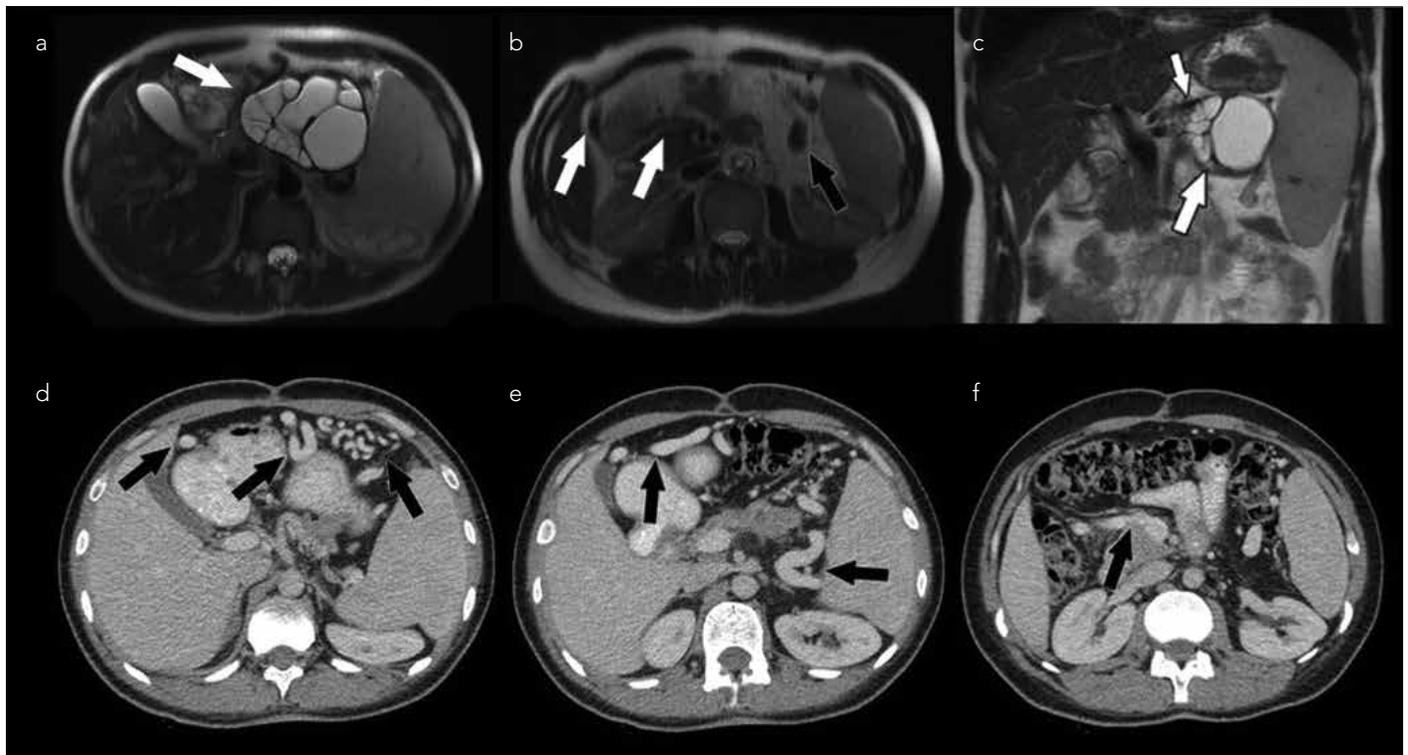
a-f. Axial (a, b) and coronal (c) MR images showing a 100×76-mm smooth bordered cystic lesion in the body and tail of the pancreas pressing against the splenic artery and vein, causing sinistral hypertension (d-f). Axial abdominal MR images showing splenic hilus and gastroepiploic vein dilatation
